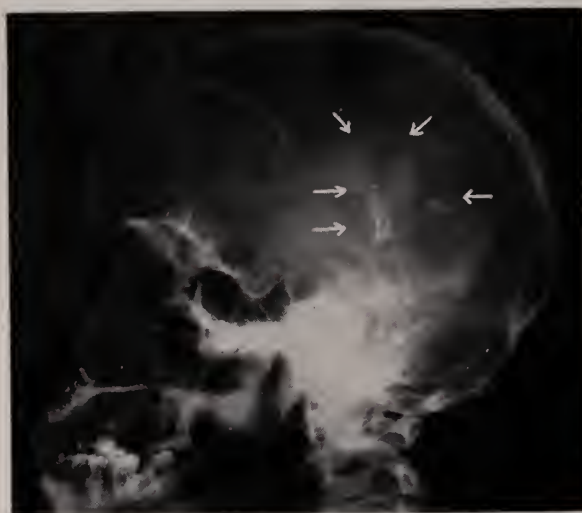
Case V. Right lateral x-ray view of skull demonstrating the extensive calcification in the right temporo-parietal region (arrows). The patient also had a left incomplete homonymous hemianopsia which disappeared after operation.
